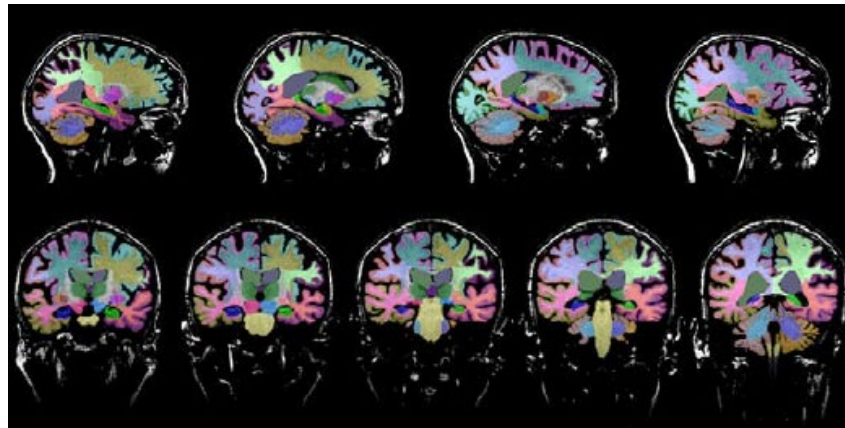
MRI has its place in sports health surveillance such as diagnosing and monitoring Chronic Traumatic Encephalopathy.
